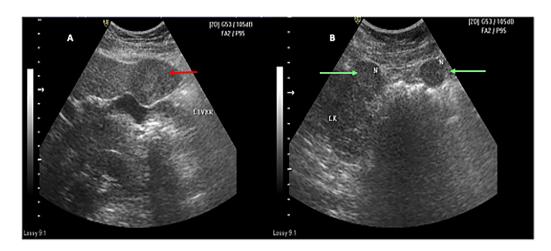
(Patient no. 1): Ultrasound of the abdomen shows a large mass in the left hepatic lobe (A, red arrow), with peri-pancreatic and para-renal lymphadenopathy (B, green arrows).
